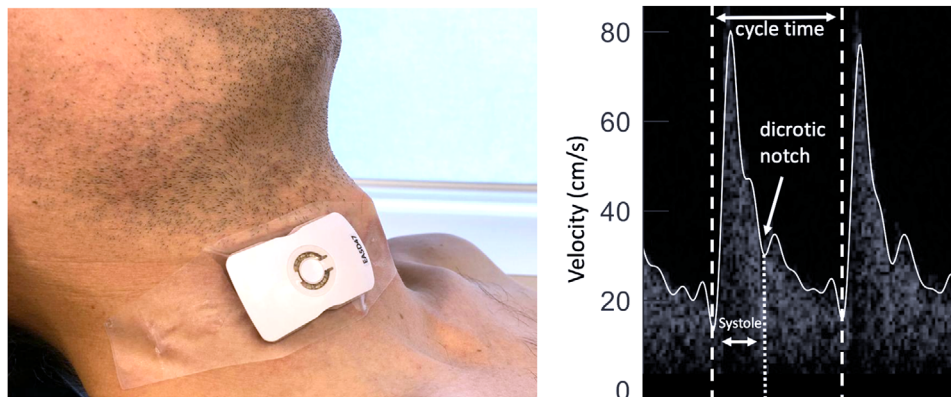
The wearable Doppler ultrasound patch with Doppler waveforms
